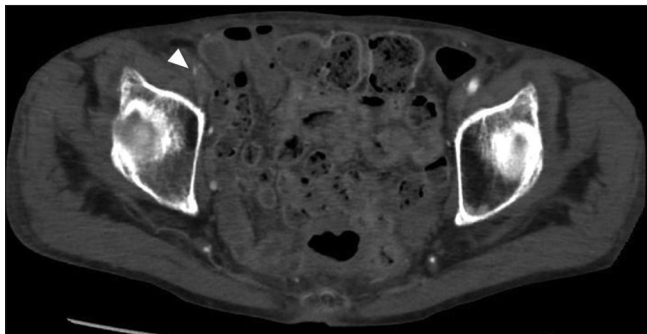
Computed tomography angiography (CTA) showed an occlusion of the right femoral artery after hemostasis. White arrow head denotes right femoral artery.
